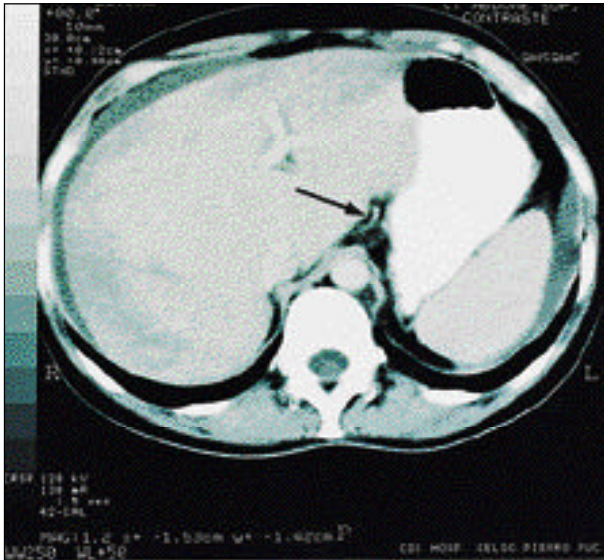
Abdominal computed tomography showing hepatomegaly with thrombosis of the inferior vena cava.
